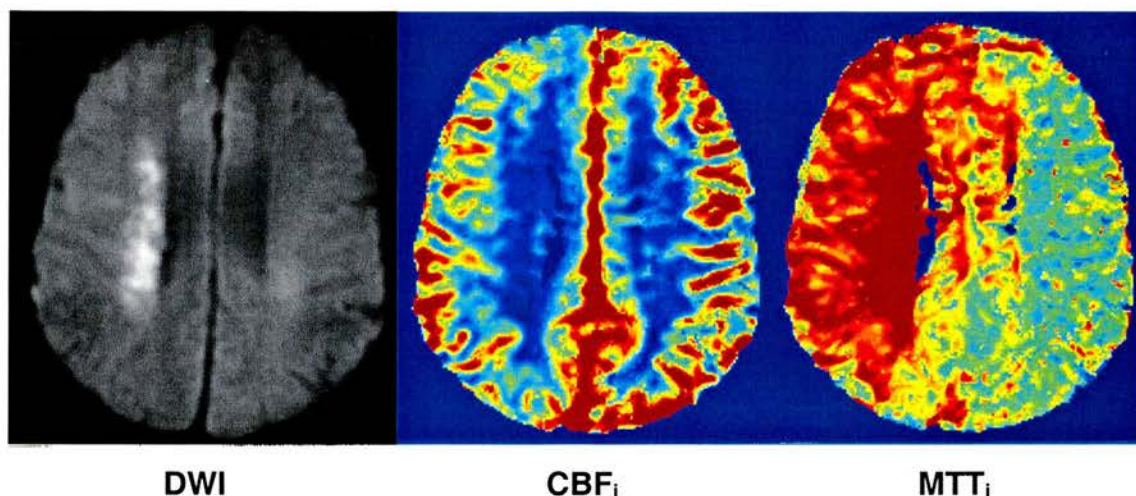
DWI, CBF_i, and MTT_i images from a patient with a right hemisphere ischaemic lesion at 13 hours after stroke onset. Note the ‘DWI/PWI mismatch’, i.e. the hyperintense lesion on DWI appears smaller than the visible lesion on the CBF_i and MTT_i images.
